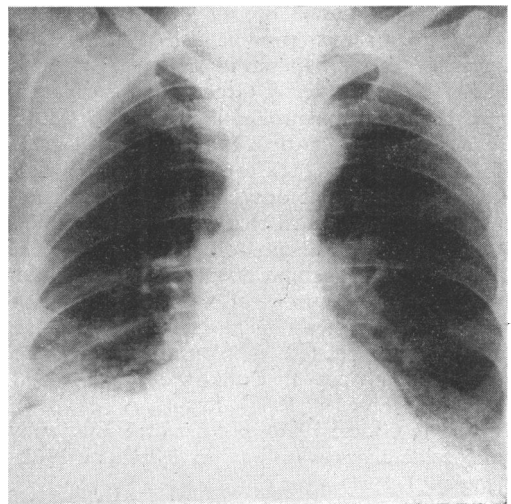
Case 2 Radiograph of chest, showing irregular opacities above the diaphragm at the bases of both lungs*
